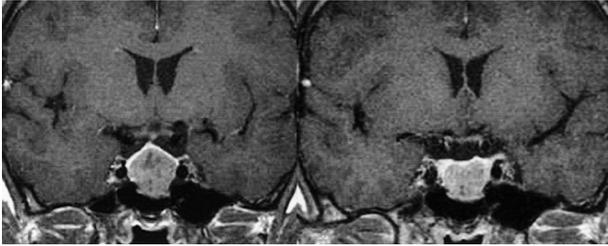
Representative coronal T1-weighted MR image with gadolinium enhancement (*left*: pre-, *right*: post-octreotide treatment) shows tumor shrinkage in a 44-year-old male acromegalic patient. With volume reduction in width as well as in height, the tumor was reclassified from Knosp grade 1 to grade 0.
